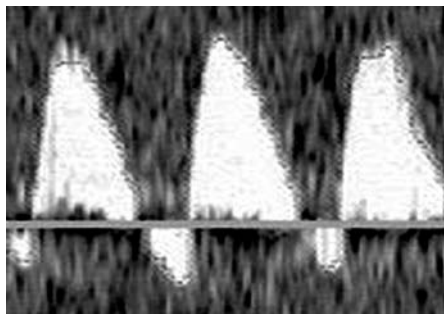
Reversed end-diastolic flow in umbilical artery Doppler.
